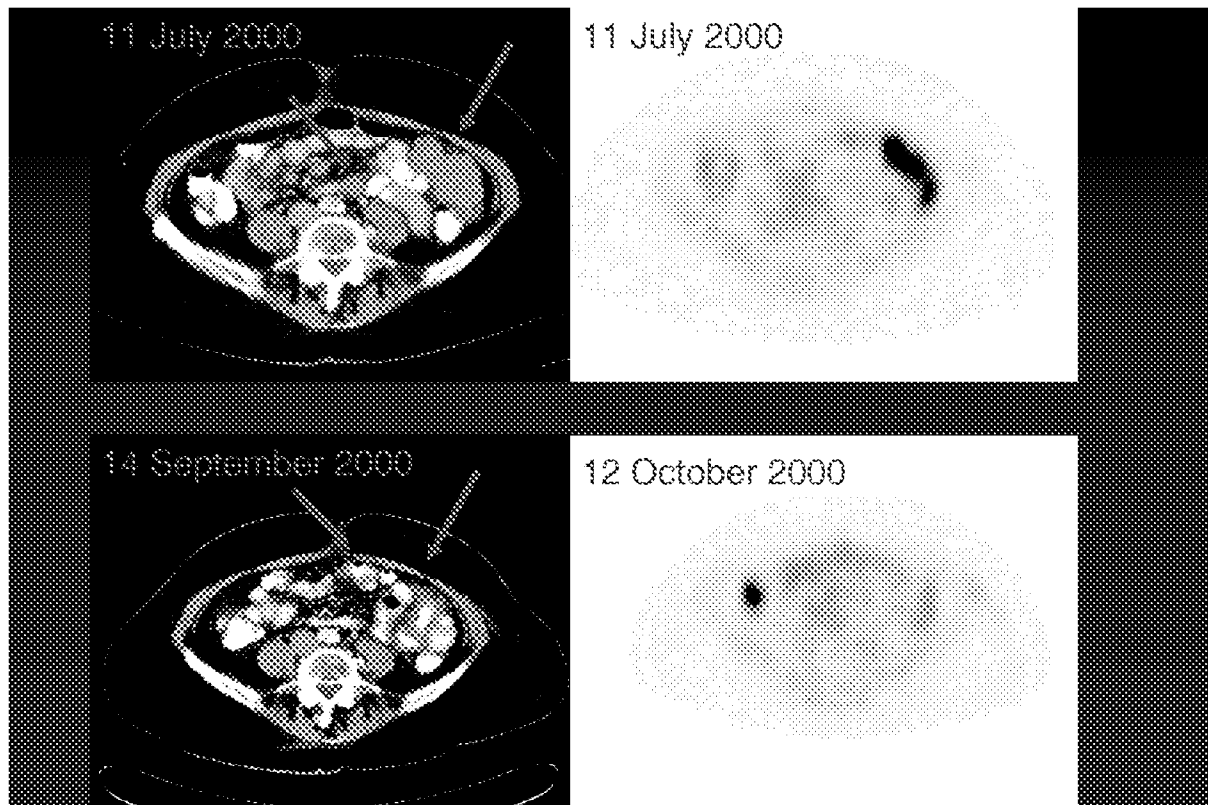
Correlative CT and PET scan responses noted in a patient with widely metastatic GIST. This patient has evidence of objective response on the serial CT scans (left side of figure), and the response is correlated with the decrease in  $^{18}\text{F}$ FDG-avidity by the tumor sites (see serial PET scans on right side of figure). The right-sided abdominal uptake on the follow-up scan is physiologic bowel uptake. This patient has continued to enjoy objective disease response more than 2 years after initiation of therapy with imatinib.
